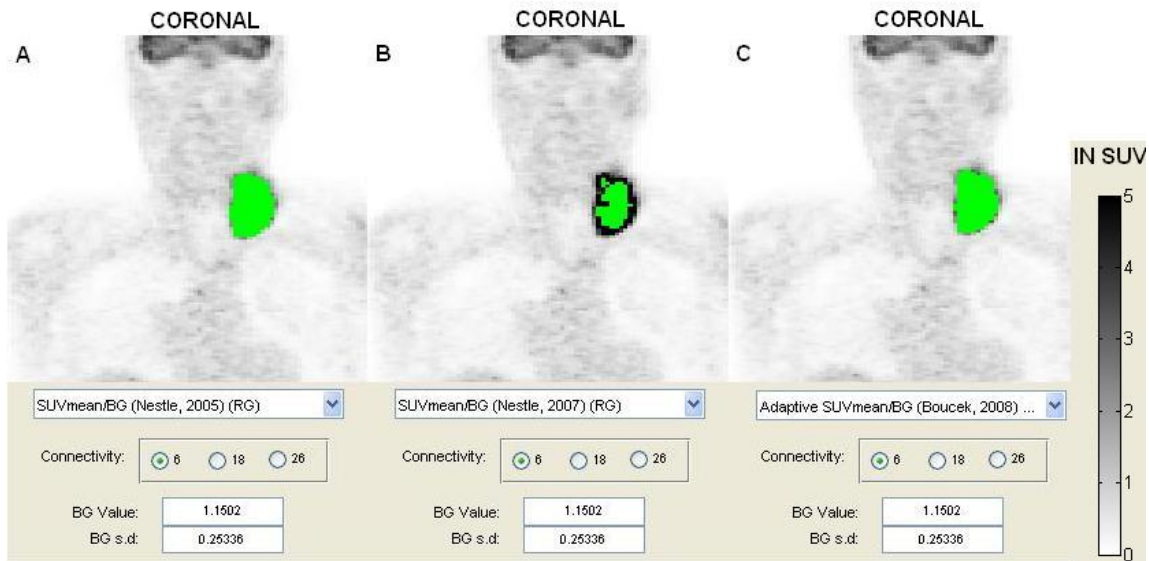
Visual Display of Segmentations using SUV_{mean} and Background
